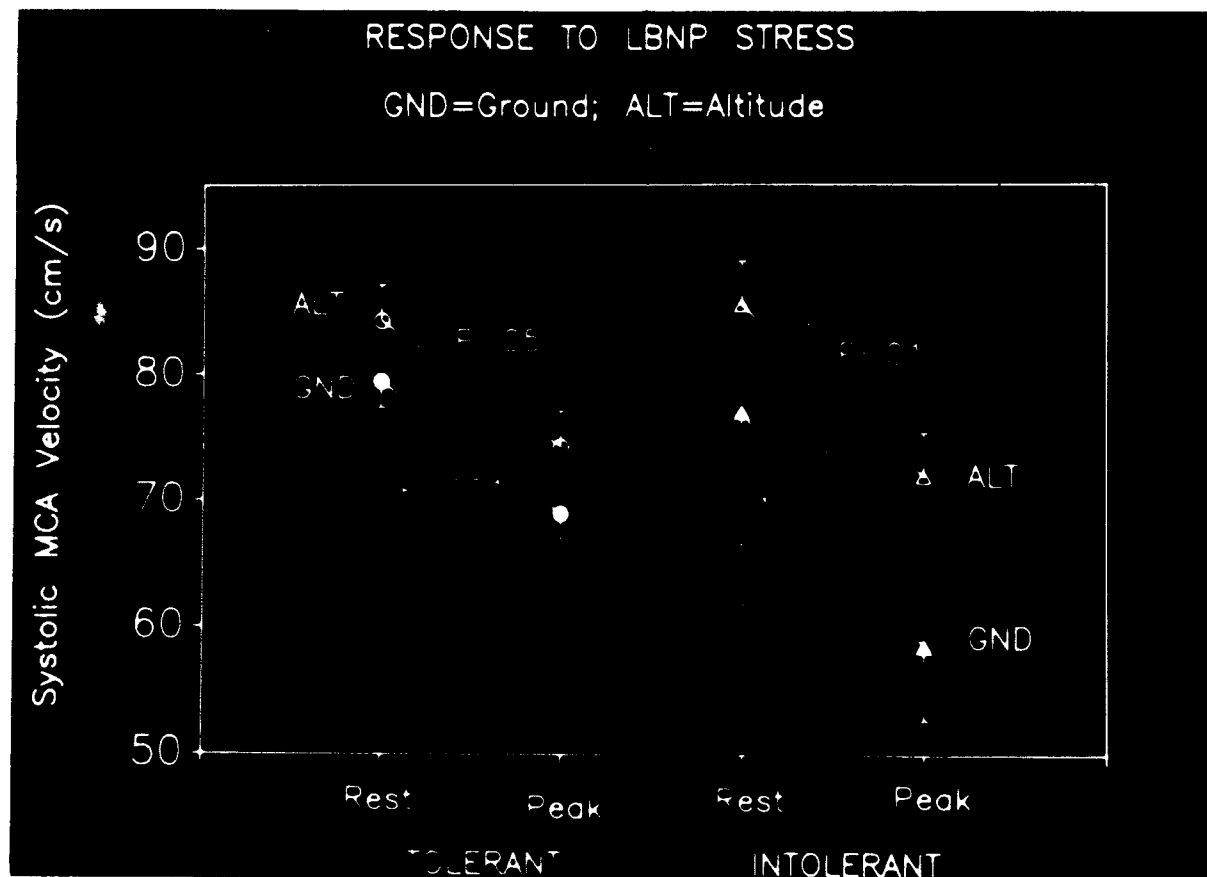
Transcranial Doppler monitoring of the systolic middle cerebral artery flow velocity (MCA) in subjects tolerant and intolerant to lower body negative pressure between rest and peak LBNP effect, at ground (GND) and altitude (ALT).
